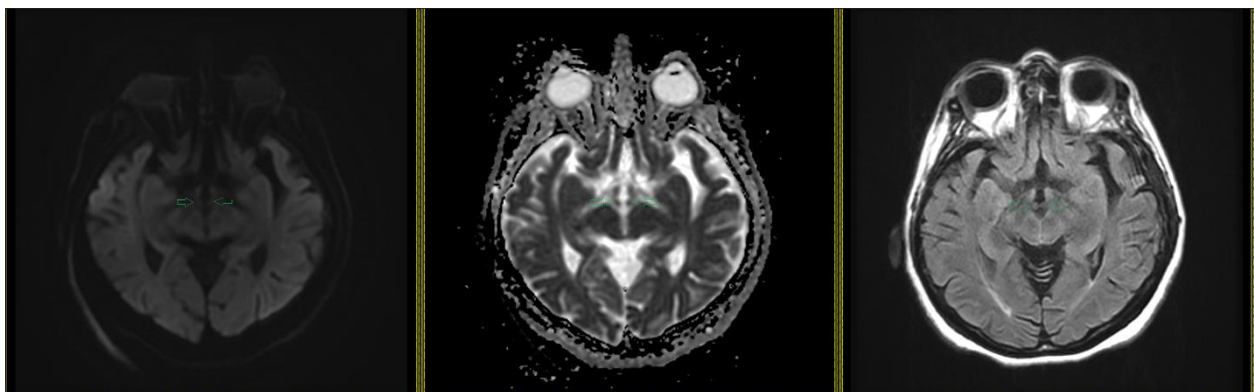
MRI brain showing no diffusion restriction within the mammillary bodies (green arrows). Mild T2 FLAIR hyperintensities noted along the periventricular white matter which may be related to chronic small vessel ischemic disease. No abnormal signal intensity visualized to suggest encephalopathy. Left: Axial Diffuse Weighted Imaging; Middle: Axial Apparent diffusion coefficient; Right: Axial T2 FLAIR, Bottom: T2 FLAIR sagittal.
